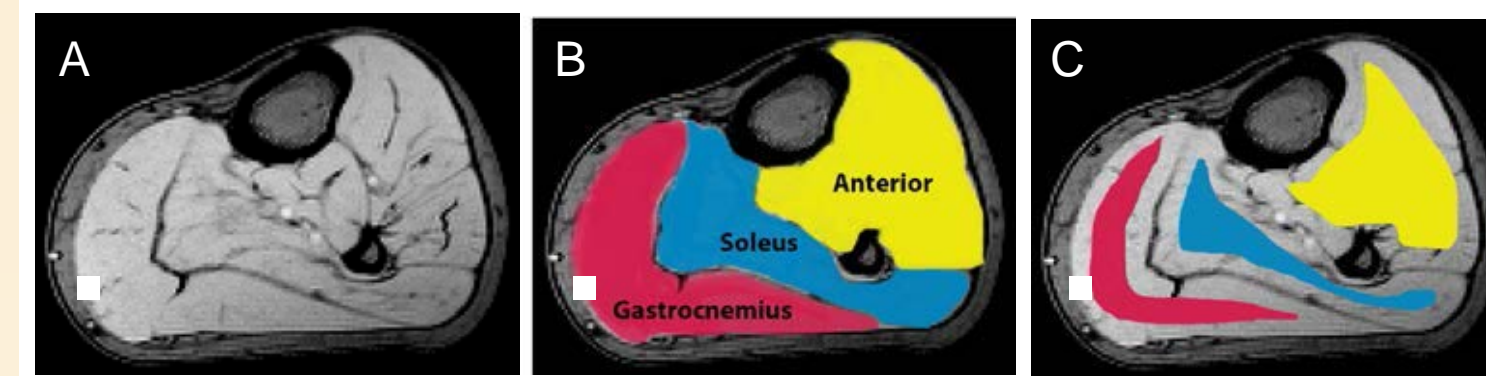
Lower leg MRI was performed on Siemens 3T Trio scanner using an acquisition protocol previously reported¹⁰. MRI-based assessment included: T1 for volume measures, T2, and FF quantification with 3-point Dixon imaging. For muscle volume measures, T1 images (A) were used to trace the surface area of a standardized slice then multiplied by the slice thickness (7mm). B. Regions of interest (ROI). C. Eroded ROI were used for T2 measures.
